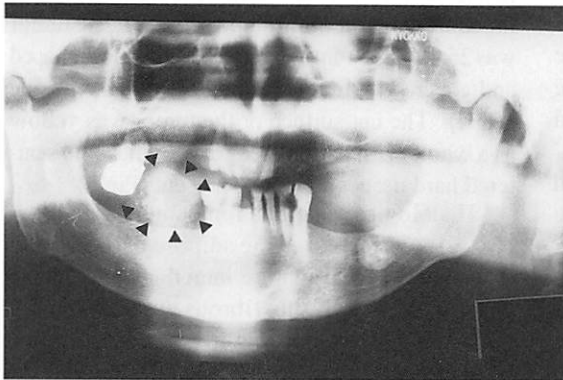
Radiograph showing a radioopaque trabeculated mass (arrows)
